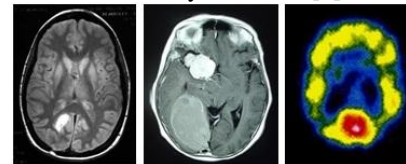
Sample Brain Tumor Images taken using MRI, CT, SPECT
